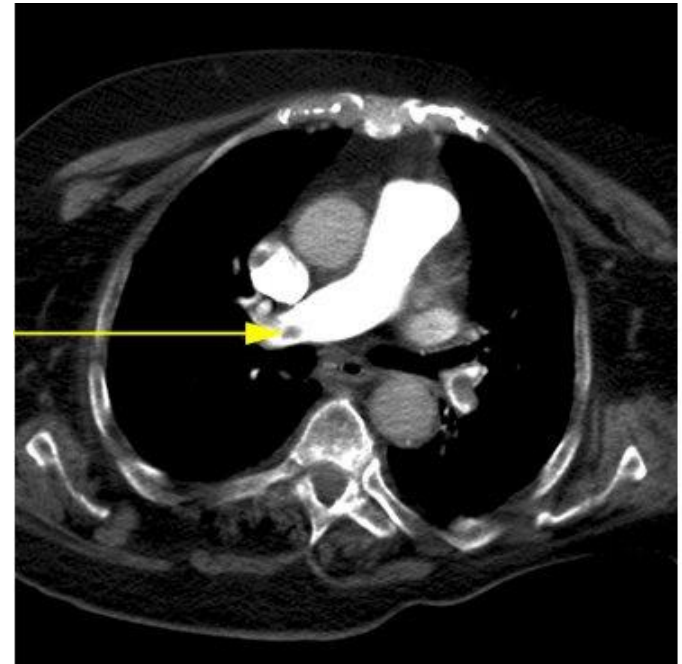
CT image showing pulmonary embolism
